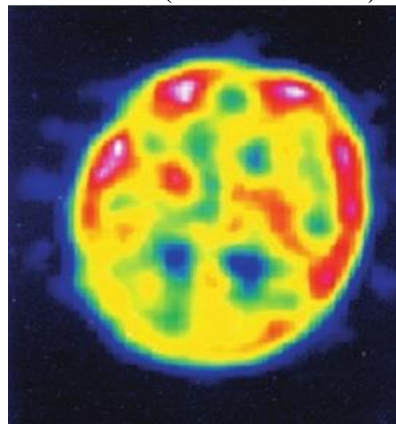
Single SPECT scan of a patient showing right temporoparietal hyperperfusion [9].
